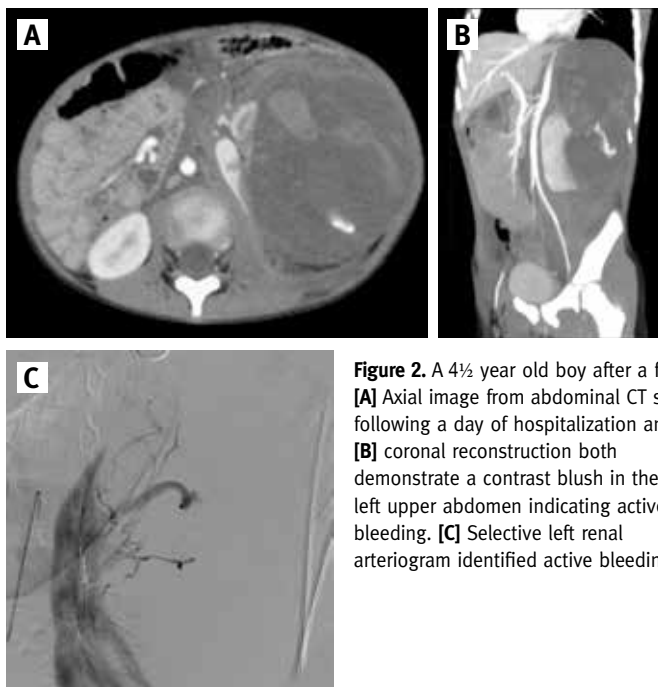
A 4½ year old boy after a fall. [A] Axial image from abdominal CT scan following a day of hospitalization and [B] coronal reconstruction both demonstrate a contrast blush in the left upper abdomen indicating active bleeding. [C] Selective left renal arteriogram identified active bleeding foci
